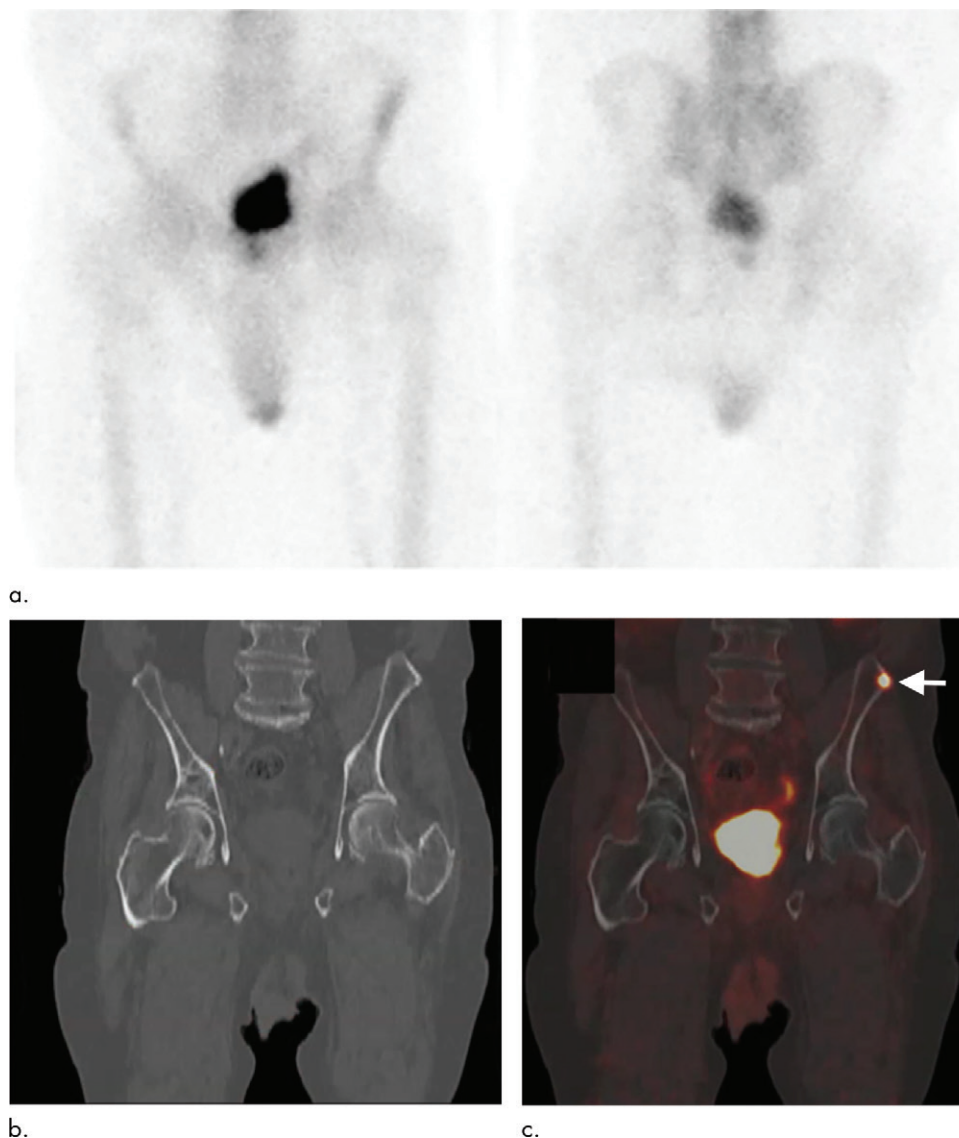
Gallium 68 (^{68}Ga) PET targeting the prostate-specific membrane antigen (PSMA) enables detection of bone metastases not visible at bone scanning in a 100-year-old man with castration-resistant prostate cancer, a rising serum prostate-specific antigen (PSA) level (81 ng/mL), and a PSA doubling time of 2.7 months. (a) Coronal anterior (left) and posterior (right) images obtained with technetium 99m scintigraphy. (b) Coronal unenhanced CT and (c) ^{68}Ga PSMA images show a false-negative result. All images were acquired within 1 month of each other. In c, there is a PSMA-avid left anterior iliac crest bone metastasis (arrow) not visible on a or b, which prompted antiandrogen targeted therapy.
